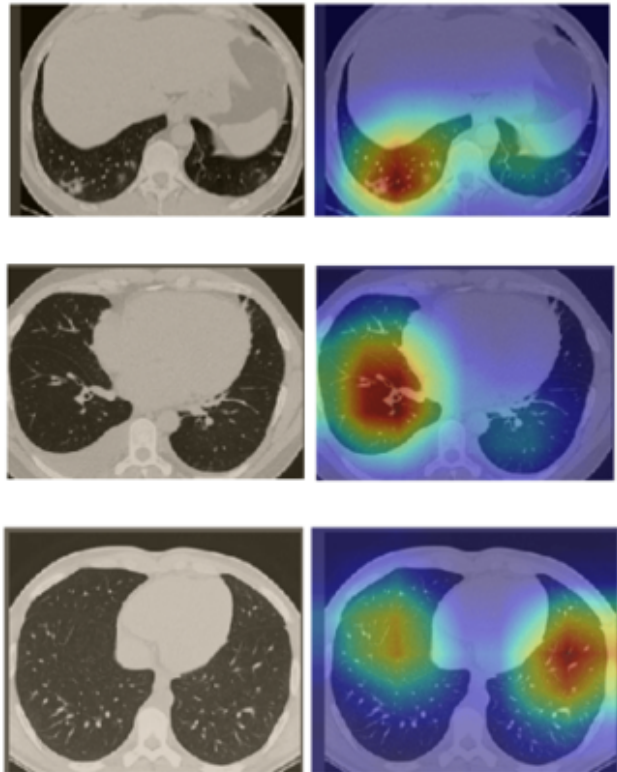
Grad-CAM visualizations for selected CT images. (Column 1: Original images of COVID-19 affected cases. Column 2: Grad-CAM visualizations showing areas of abnormalities in the CT scans.)
